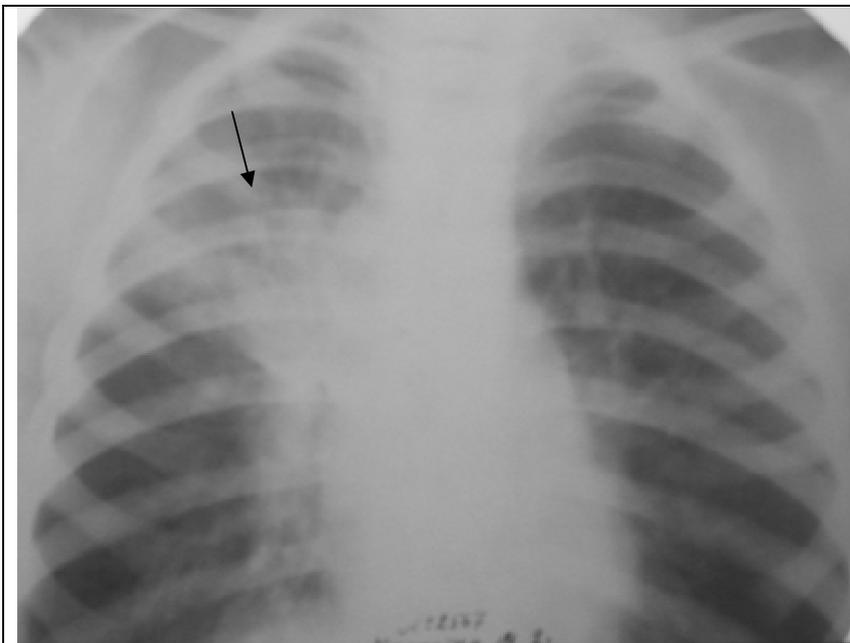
The frontal chest radiograph. The frontal chest radiograph (the patient of 16 years). In the field of a hilum of the right lung the limited shadow with indistinct contours (arrow). The hypoinflation in projection of the right upper lobe. Primary tuberculous lymphadenitis on the right (infiltrative form).
